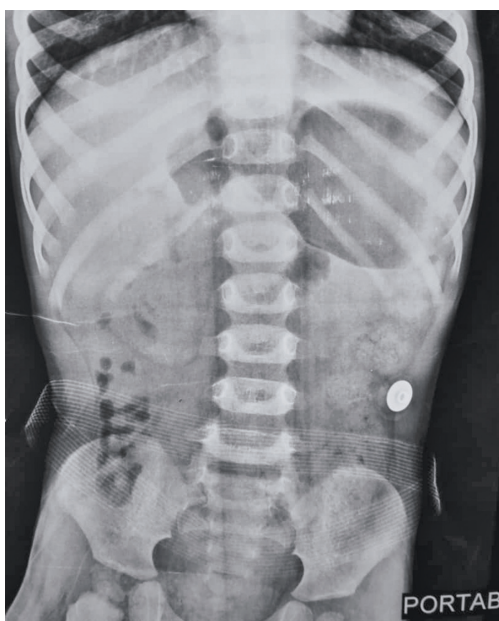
Abdominal radiograph. The stomach and the duodenum are distended with the presence of distal bowel gas.
